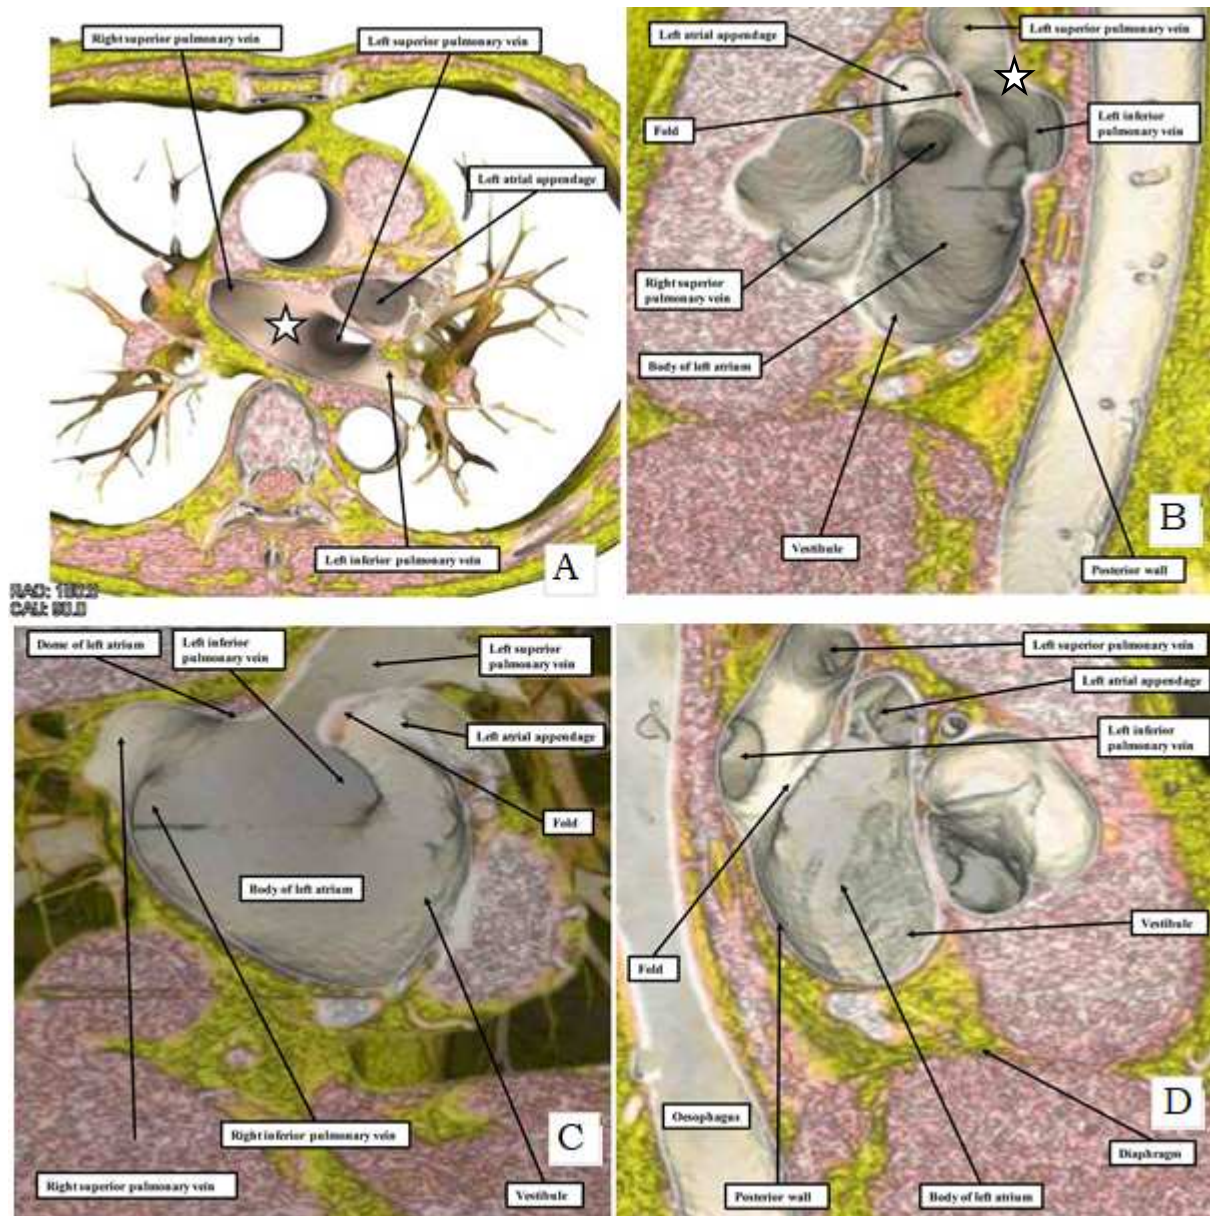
Transverse (A) and sagittal (B) computed tomographic sections, demonstrating the anatomical relations of the left atrial dome, marked by a star in both images. Coronal (C) and sagittal (D) computed tomographic sections, demonstrating the superior location of the left atrial dome, into which the pulmonary veins enter, relative to the body of the left atrium and the true posterior wall.
